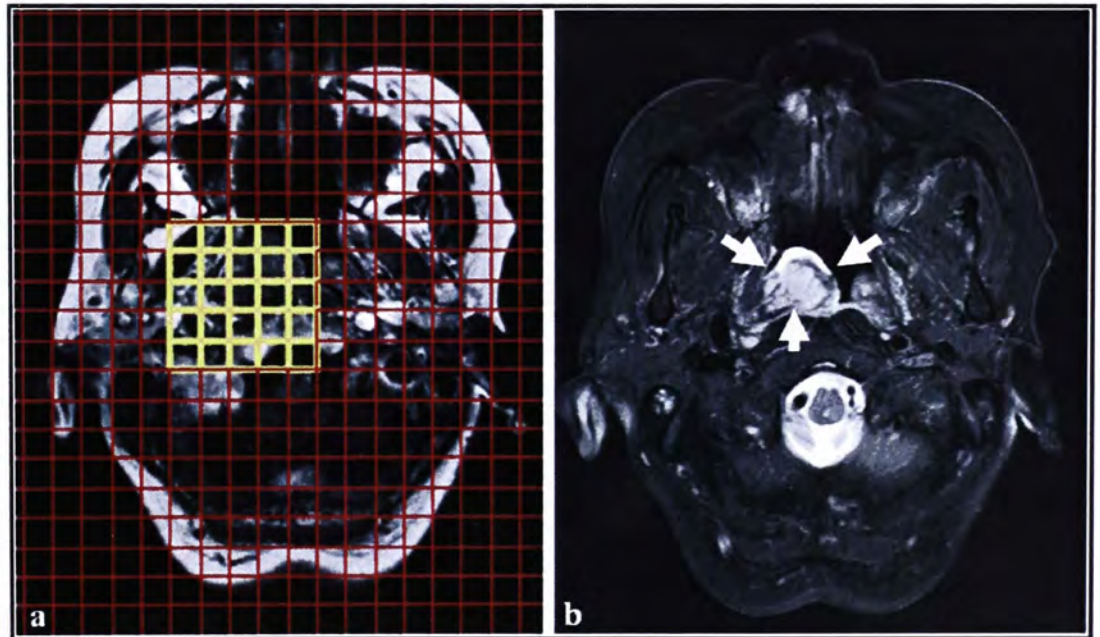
MRI images of a 70-year-old patient with NPC (subject 11).
